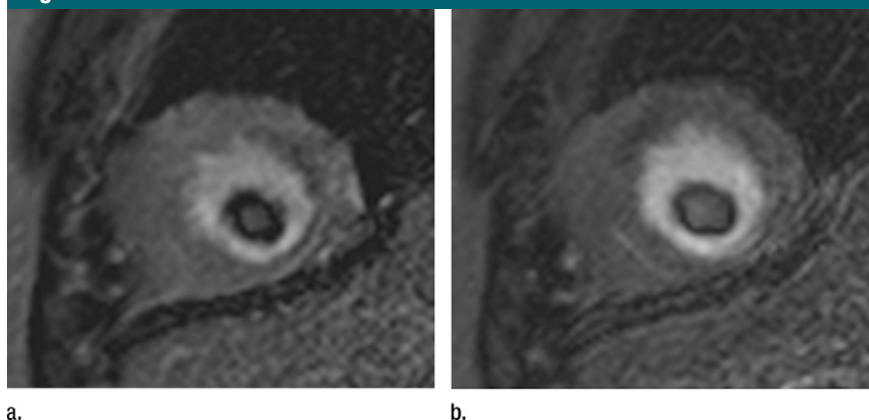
Apical thrombus is visualized in both (a) 2D and (b) 3D short-axis LGE MR images with inversion times optimized for myocardial nulling in 65-year-old man with subacute myocardial infarction.
